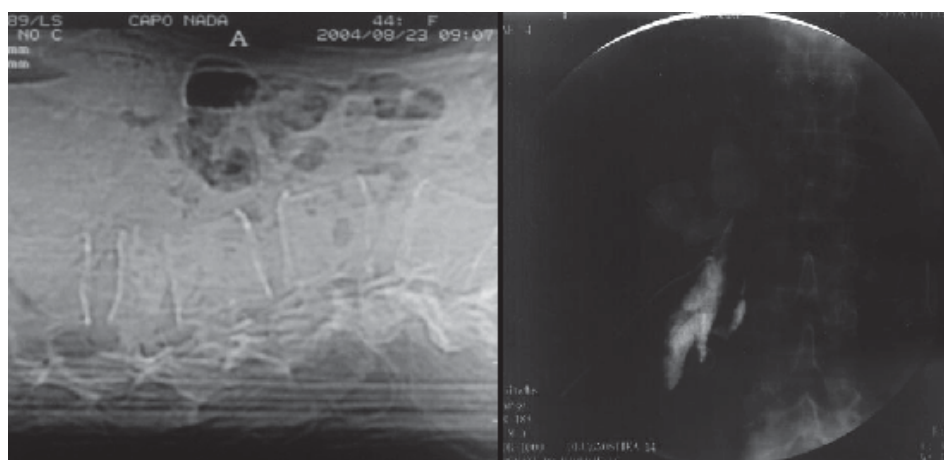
Computed tomography and radiography of lumbar spine show a psoas abscess in the presented patient.
